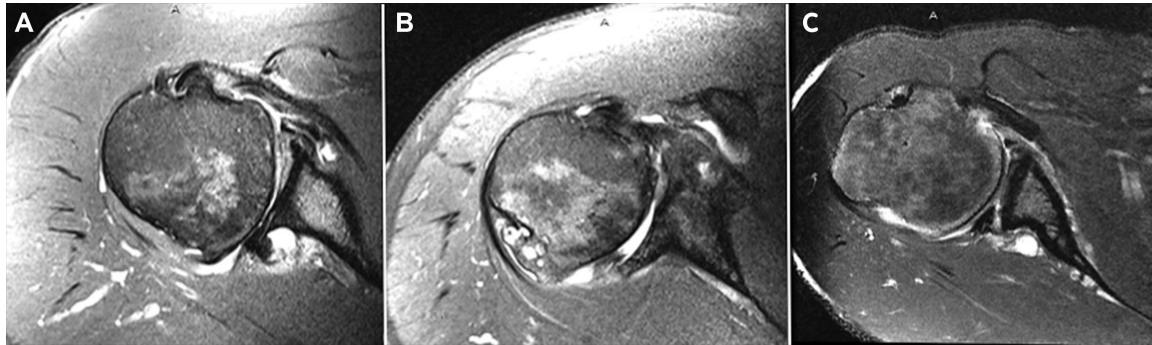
Axial magnetic resonance images of right shoulders demonstrating Walsh type B and C glenoids. (A) A B1 glenoid with posterior wear and slight posterior subluxation of the humeral head on the glenoid. (B) A B2 glenoid with a biconcave shape and posterior subluxation of the humeral head. (C) A type C glenoid with congenital retroversion.
